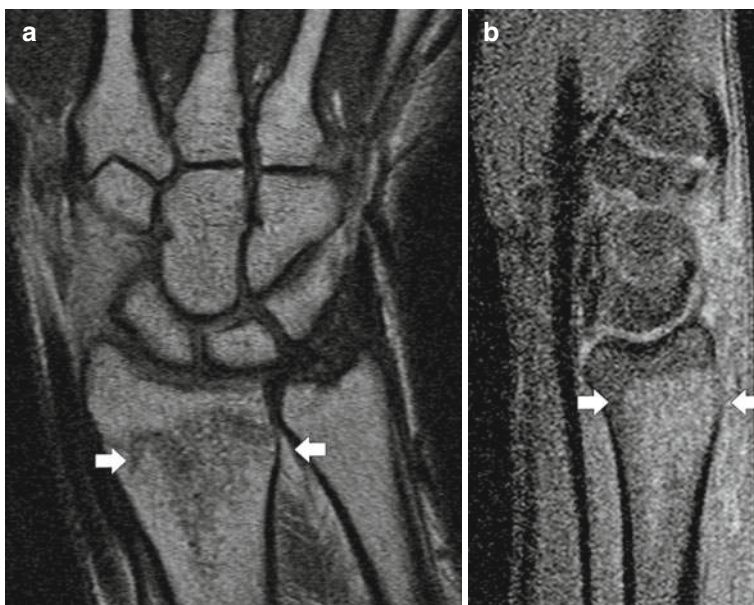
Distal radial fracture. Wrist MR anteroposterior T1-weighted (a) and lateral T2-weighted (b) images reveal abnormal signal intensity indicating a fracture
